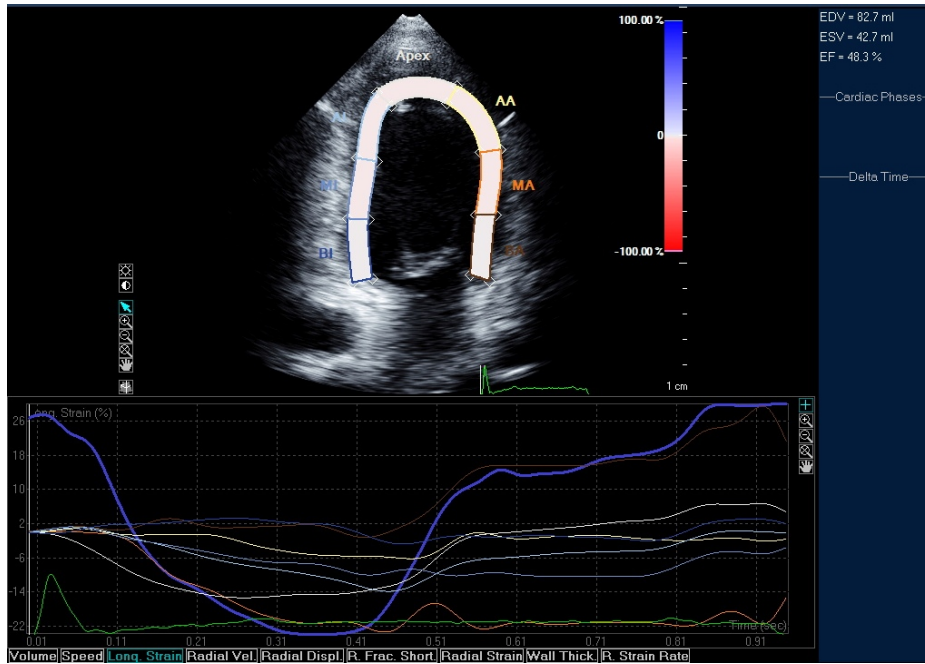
(b): Longitudinal Strain in the same patient obtained in Apical 2 chamber view.
